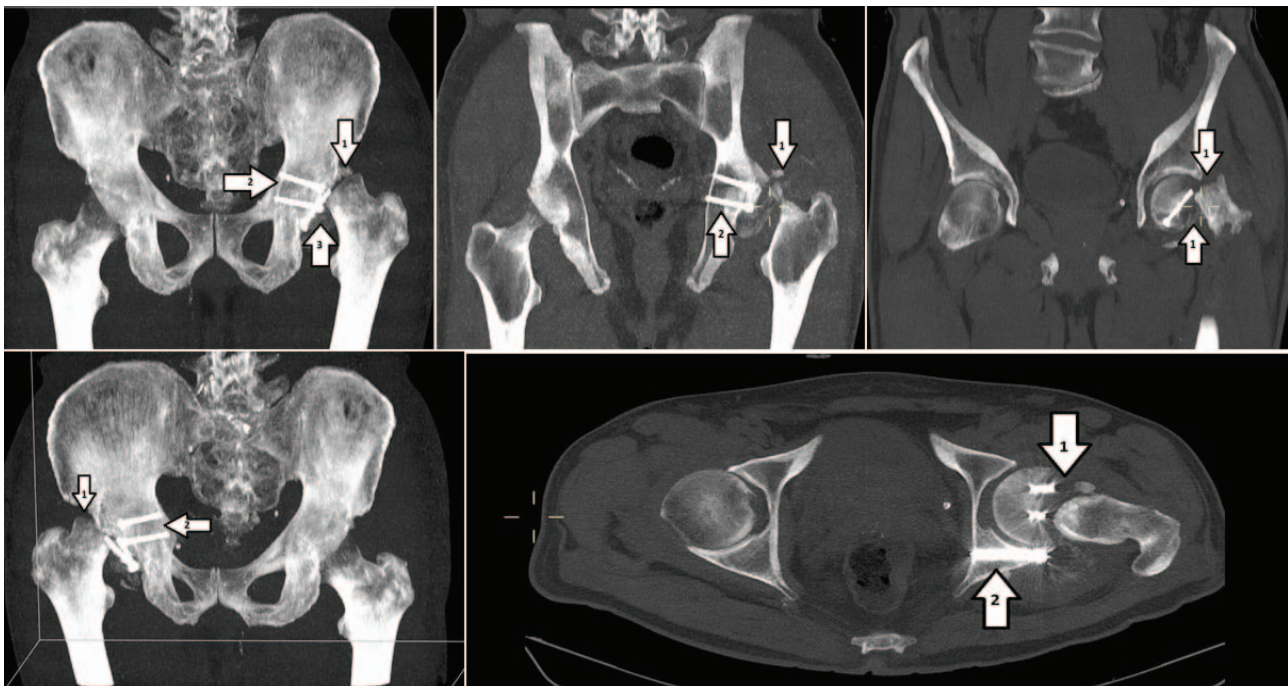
Computed tomography 3D reconstruction of the pelvis with both hips: stress fracture of the left femoral neck. Arrow 1: Stress fracture of the femoral neck; Arrow 2: Healed acetabular fracture – posterior wall; Arrow 3: Healed fracture of the femoral head.
